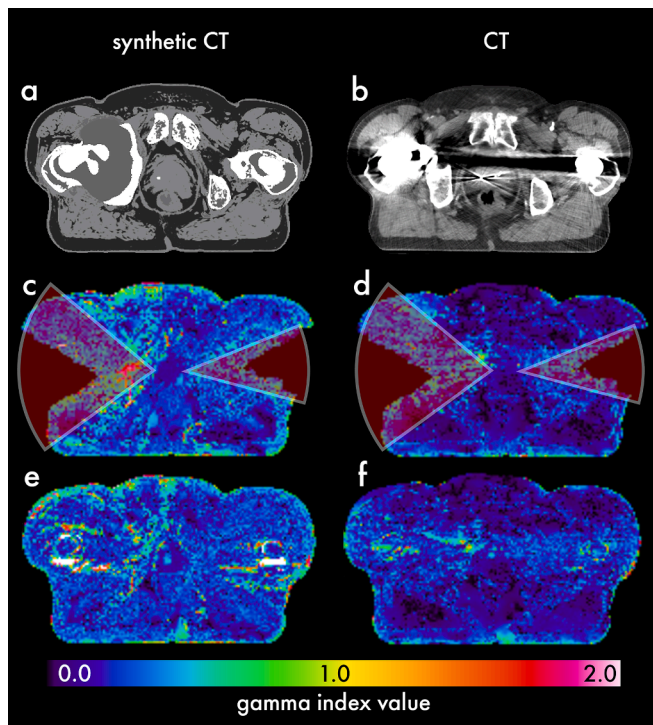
A-b: axial slice of the synthetic ct (sct) and ct images. c-d: calculated gamma index values against the metal artefact reduction (MAR) CT for the partial arc plans, accompanied by the avoidance sectors. e-f: Gamma index values for the full arc plans.
